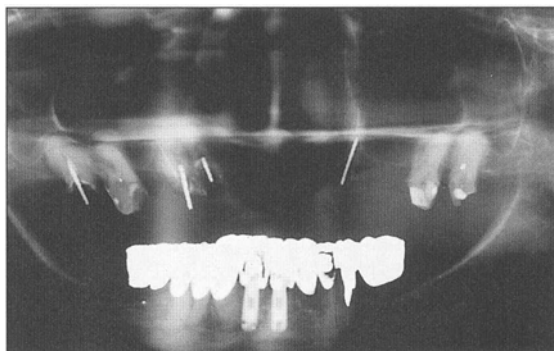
7a Preoperative panoramic radiograph. There is minimal crestal bone inferior to the sinus.
